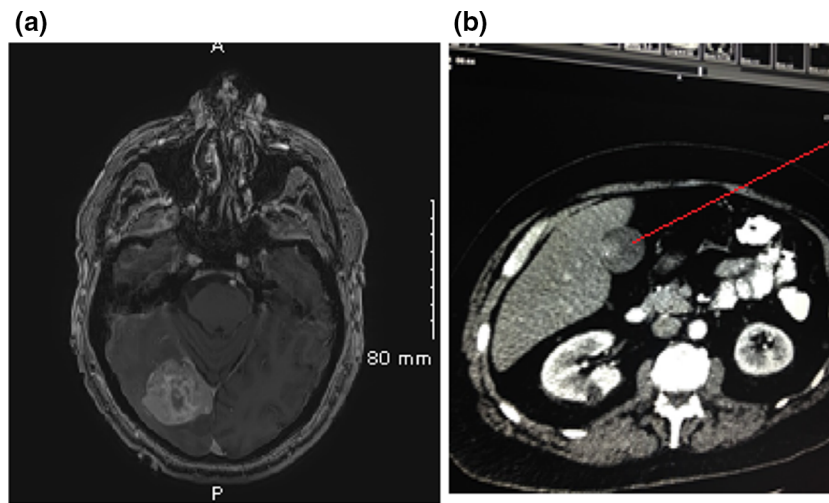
a MRI brain showing RT metastatic melanoma, and b MRI abdomen showing mass in gall bladder (*red line*). MRI magnetic resonance imaging
